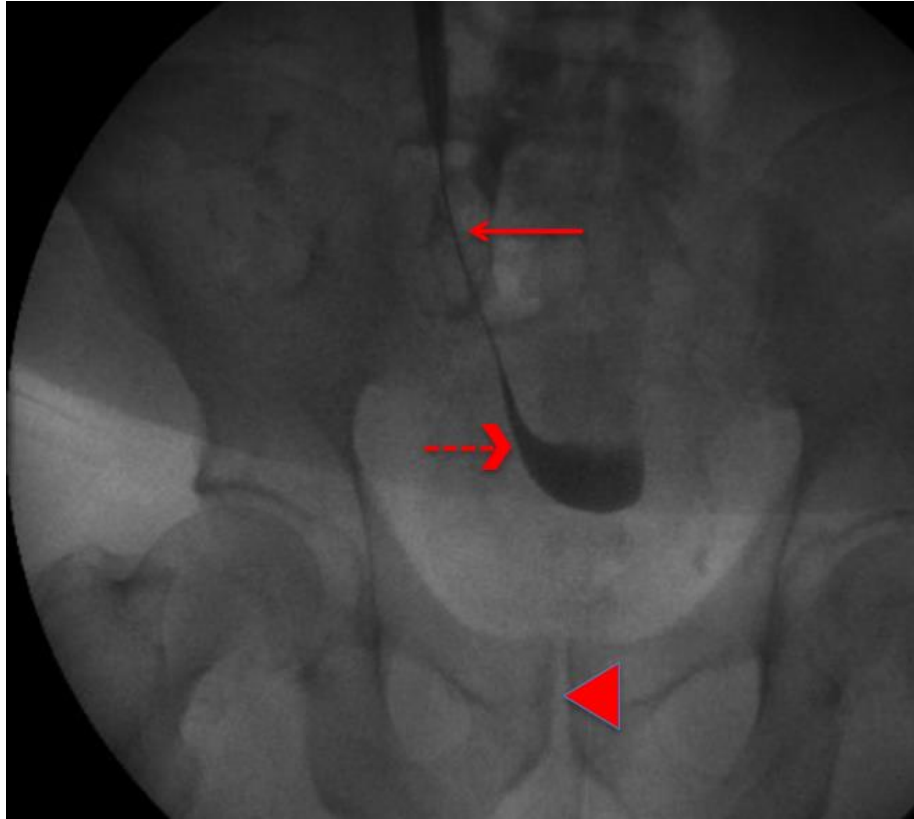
Fluoroscopic radiograph of peritoneal dialysis catheter insertion; Injection of radiocontrast followed by modified Seldinger technique. Standard anterior-posterior pelvic view, with the patient in the supine position (solid arrow – needle & guidewire, dashed arrow – pooled radiocontrast, arrowhead – pubic symphysis).
